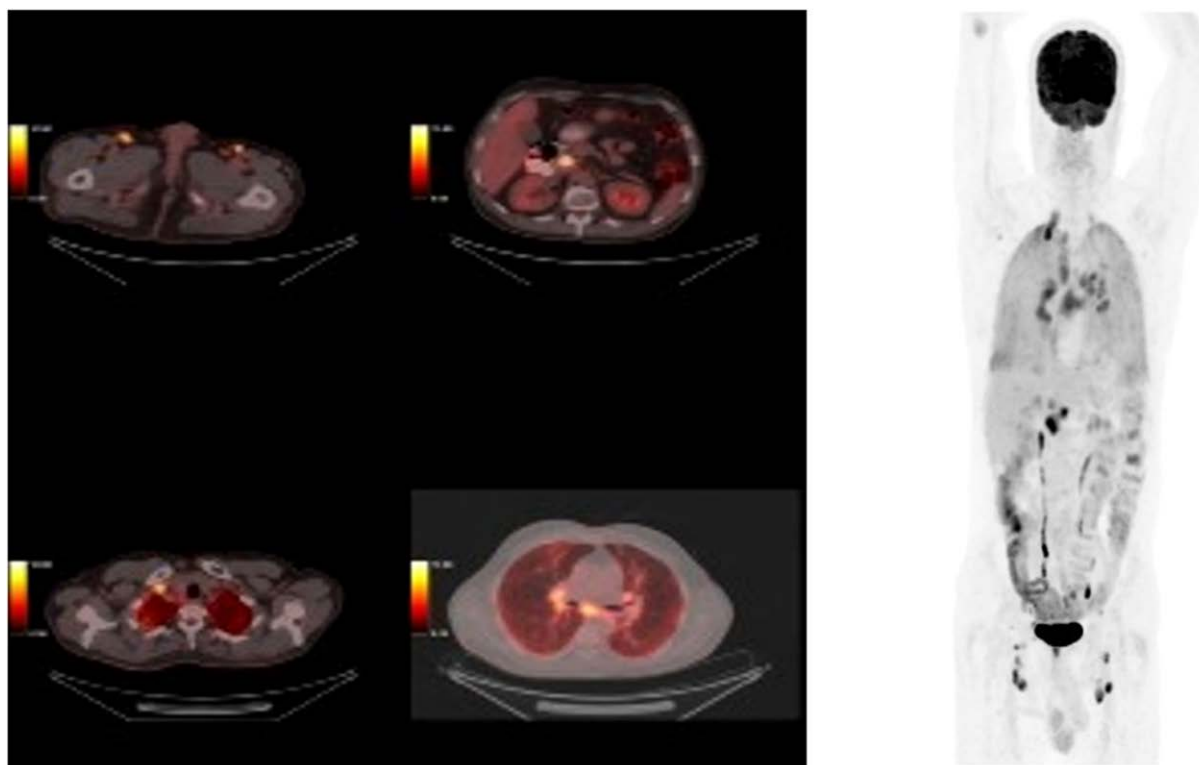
presents a portion of the  $^{18}\text{F}$ -FDG-PET/CT scan of a 54-year-old woman, which reveals hypermetabolic lesions in the left cervical, mediastinal, right upper and lower paratracheal, subcarinal, and left lower paratracheal lymph nodes. The lymph node exhibiting the highest glucose metabolism was located in the right upper paratracheal region, measuring  $19 \times 17$  mm with a SUVmax of 16.68. Pathological examination of lymph node biopsies from stations 4R and 7 revealed caseous necrotizing granulomas, and tissue samples tested positive for *Mycobacterium tuberculosis* by PCR. The patient was subsequently diagnosed with TB and initiated on appropriate treatment.
